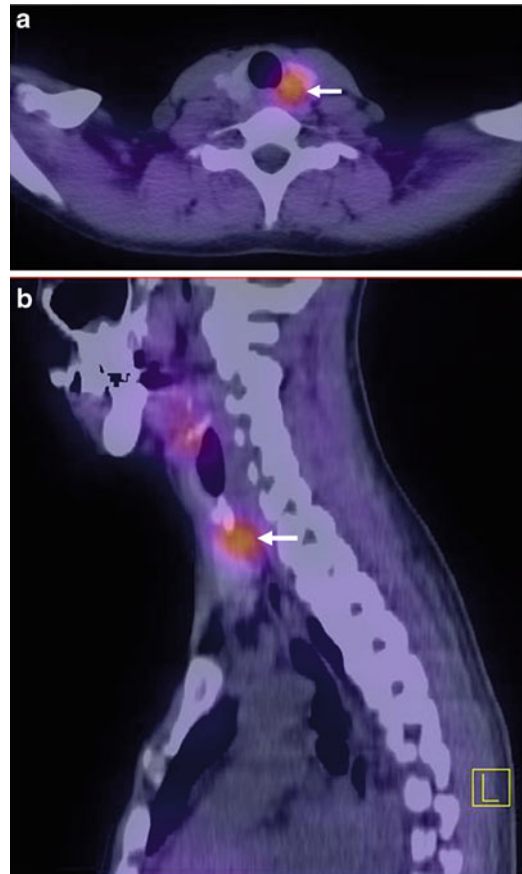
Ectopic parathyroid adenoma. Sestamibi SPECT/CT demonstrates a sestamibi-avid soft tissue nodule (*arrow*) immediately posterior to the superior aspect of the left thyroid lobe. Transverse (a) and sagittal (b) coregistered SPECT/CT tomograms. Later, a parathyroid adenoma was surgically resected from this site
